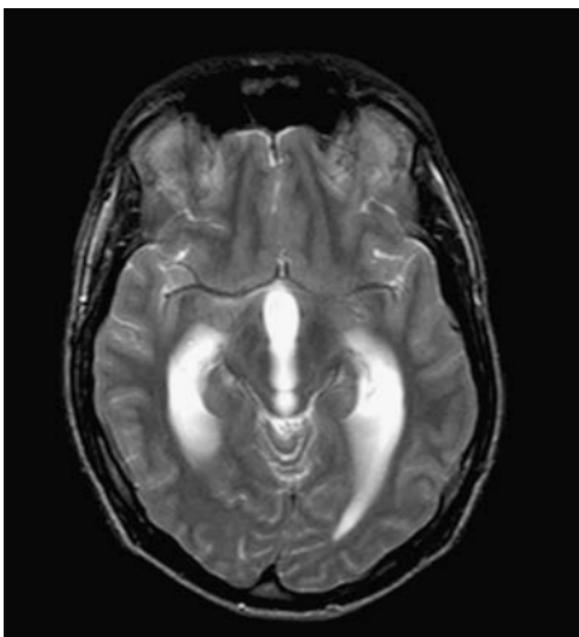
Aqueduct stenosis. (a) Thin section T2W sagittal and (b) axial T2W MRI. Typical beaking/tapering of the inferior aspect of the lumen of the aqueduct of Sylvius ((a) white arrow) resulting in obstruction to CSF flow and proximal hydrocephalus reflected by dilatation of the superior portion of the aqueduct and of the third and lateral ventricles (b).
